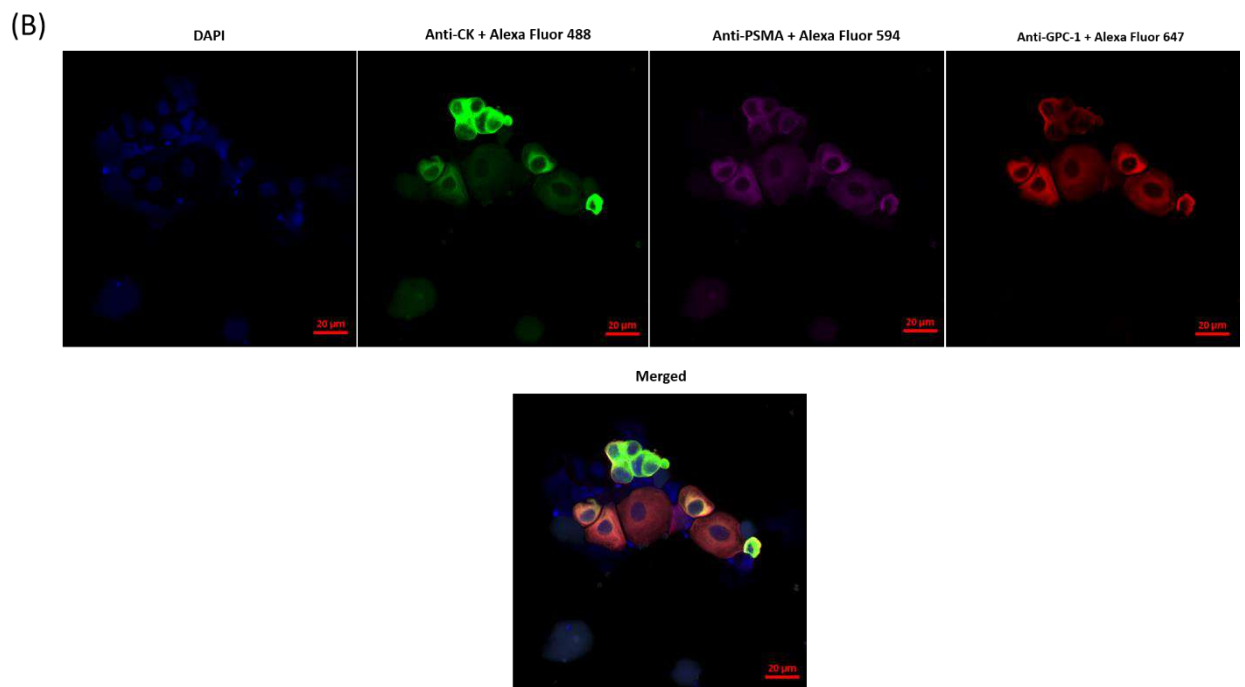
A diversity of putative tumour cells isolated from the patients' semen samples. The putative tumour cells positive for all three antigens (PSMA, CK and GPC-1) were considered DTCs (A). At the same time, a high number of the putative tumour cells significantly positive for one or two of the three antigens was also observed in the patients' samples (B).
